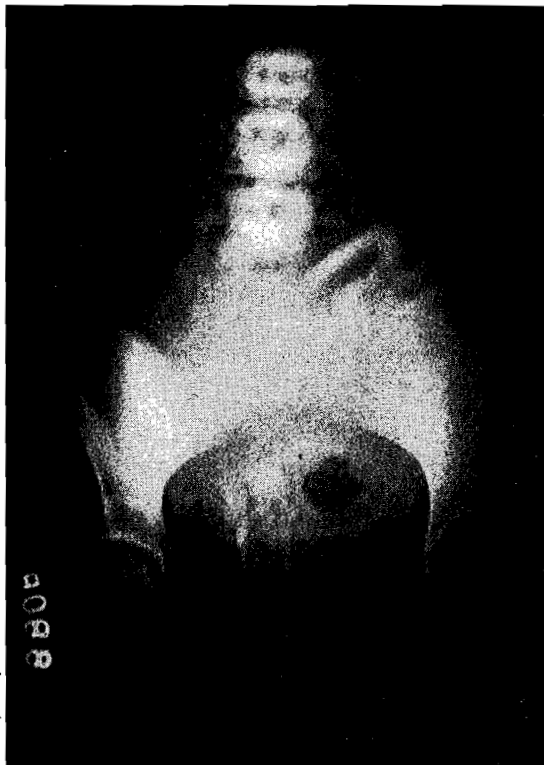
Anencephalus. Diagnosis before delivery by the X-ray. Stillborn monster delivered spontaneously—face anterior presentation. Note the complete absence of the cranial bones; the foetal spine is seen in the maternal pelvis.
